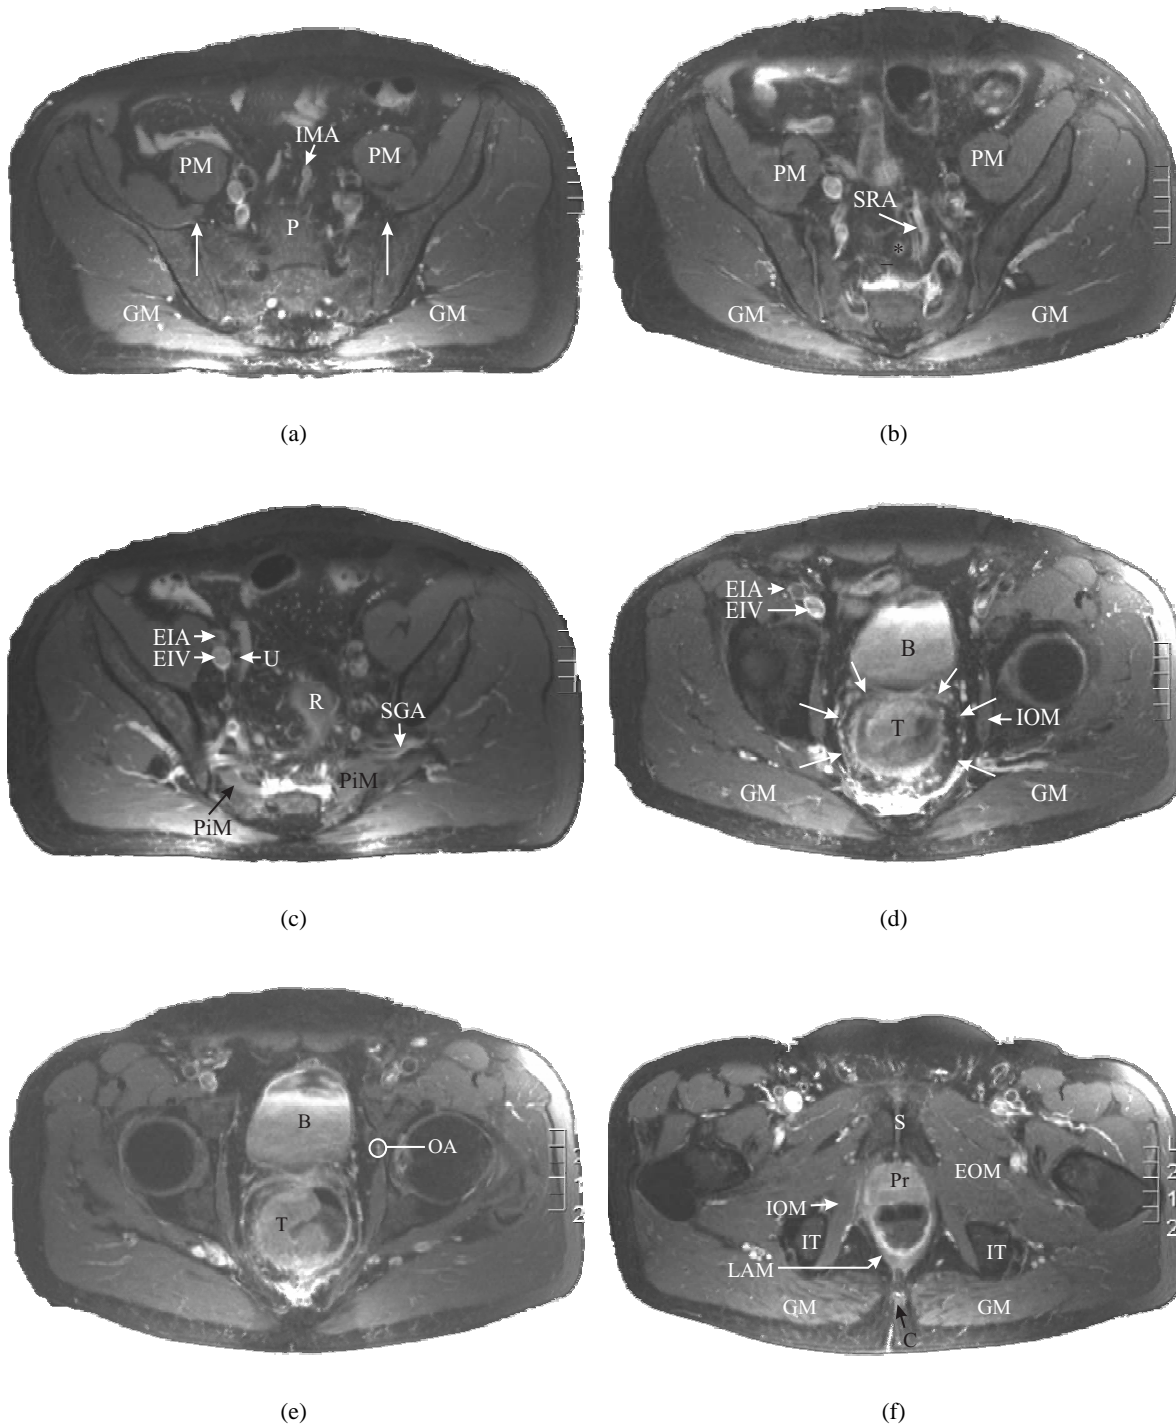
Transverse view through 6 selected levels from cranial (a) to caudal (f) direction. Images are T2 weighted magnetic resonance images. *Abbreviations:* B: bladder; C: coccyx; EIA: external iliac artery; EIV: external iliac vein; EOM: external obturator muscle; GM: gluteus maximus muscle; IMA: inferior mesenteric artery; IOM: internal obturator muscle; IT: ischial tuberosity; LAM: levator ani muscle; OA: obturator artery; P: promontory; PiM: piriform muscle; PM: psoas muscle; Pr: prostate; R: rectum; S: symphysis pubis; SGA: superior gluteal artery; SRA: superior rectal artery; T: tumour; U: ureter. The two arrows in (a) indicate the sacro-iliac joint. The black asterisk in (b) indicates a suspect lymph node along the SRA.
